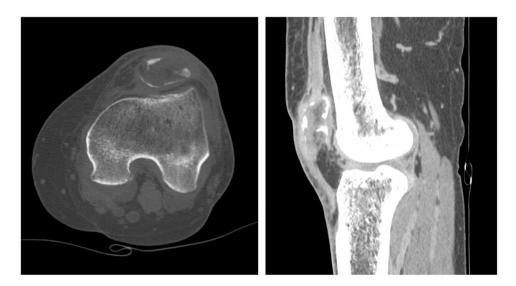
Noncontrast CT of the left patella shows a lytic lesion both on axial and sagittal views. Low-attenuated marrow replacing lesion of almost the entire patella with significant cortical loss is evident. Focal area of soft tissue extension to the patellar tendon is also noted.
